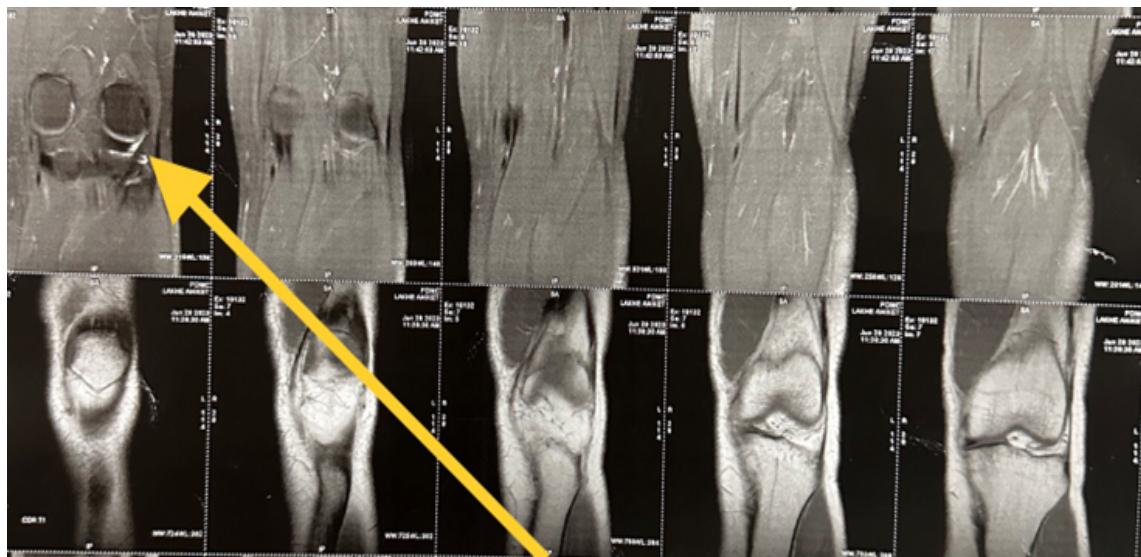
MRI left knee-Coronal sections
